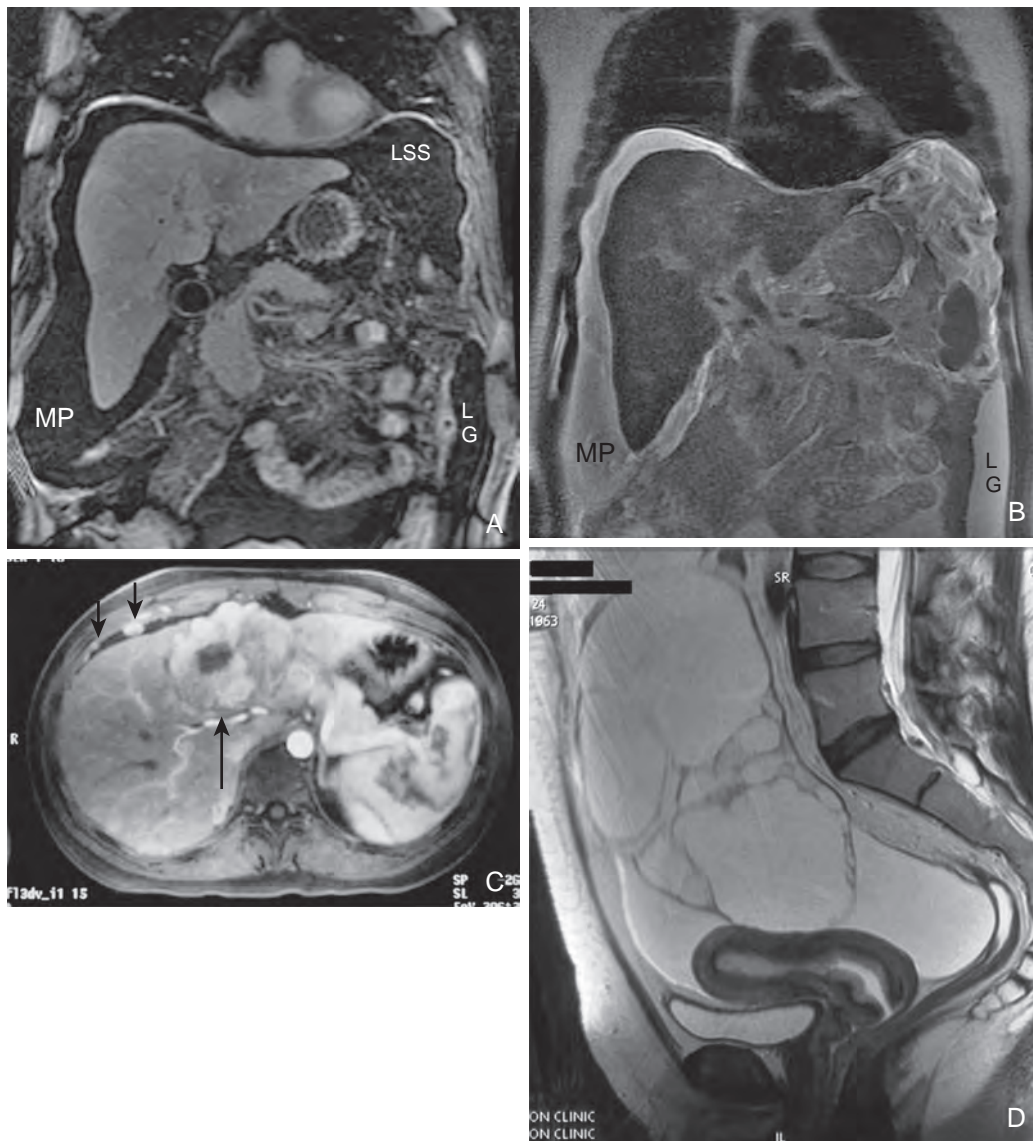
Ascites: MR features. Coronal T1-weighted (A) and T2-weighted (B) scans of the upper abdomen show benign fluid in Morison's pouch (MP), left paracolic gutter (LG), and left subphrenic space (LSS). C. Image of a patient with fibrolamellar hepatoma of the left lobe shows ascites and enhancing Glisson's capsule implants (arrows), indicating peritoneal spread of disease. D. Coronal T2-weighted image shows pseudomyxoma peritonei displacing the gut superiorly. (D courtesy Dr. Rodney H. Reznek, London, England.)
